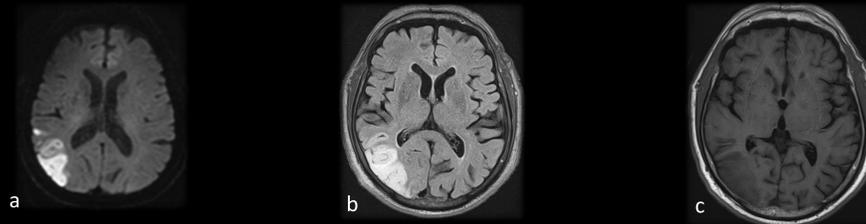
Brain magnetic resonance imaging showing right acute non-hemorrhagic right parieto-occipital cortical infarct in diffusion-weighted imaging (a), fluid attenuated inversion recovery (b) and T1-weighted sequences (c).
